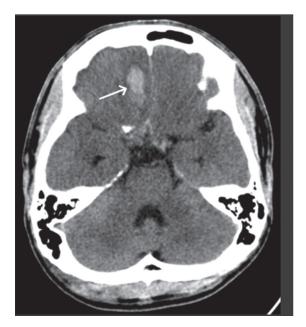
Axial cranial CT scan (brain window) shows a well-defined hyperdense lesion with mild perilesional edema at the inferior aspect of right frontal lobe (arrow), compatible with cerebral contusion.
